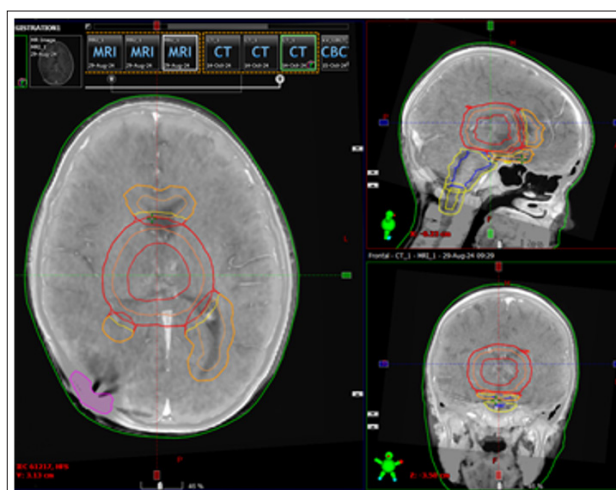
Delineation of the Clinical Tumor Volumes CTVp in the Area of the Primary Tumor and CTV ventr. in the Area of the Lateral Ventricles after Fusion of the Primary Preoperative MRI with the Planning CT.
